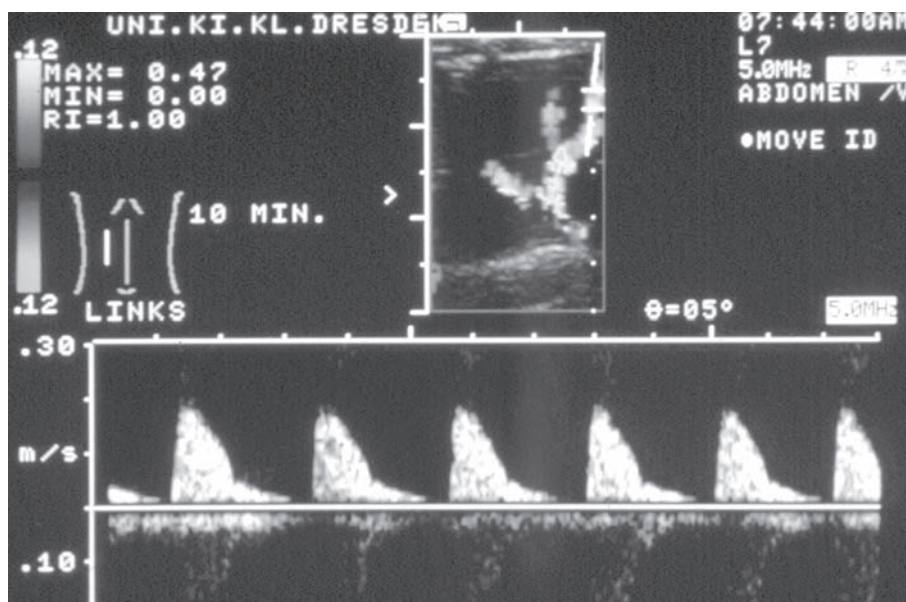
The same infant as in Figure 2 with false-positive, abnormal finding in renal Doppler sonography (RI=1.0).
